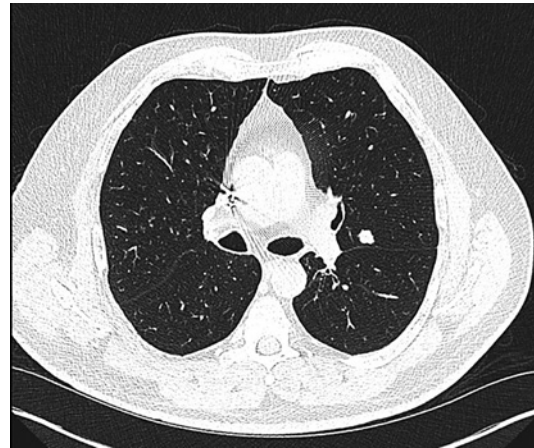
Axial view of the CT scan of the lungs, 6 months prior to the development of TLS. A solid nodule of 11 mm × 8 mm is visible in the inferior portion of the left upper lobe.
